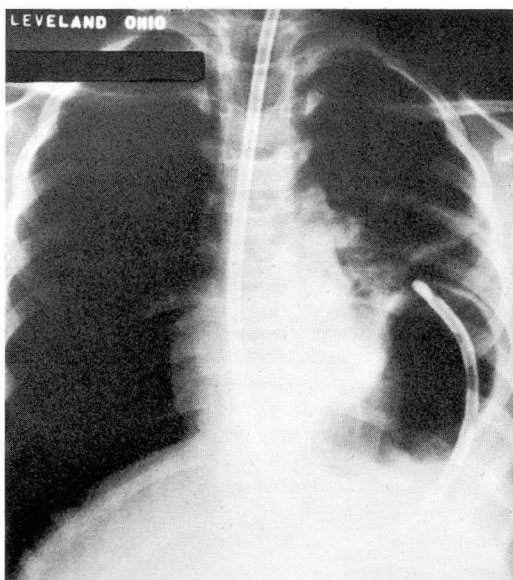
Passage of the nasogastric tube into the viscus demonstrates on the roentgenogram that it is stomach. The distention is decreased after suction.
